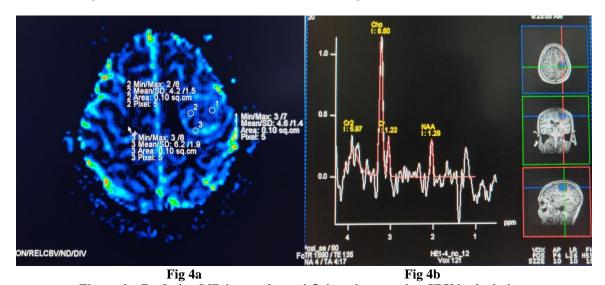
Perfusion MR image shows 4-5 times increase in rCBV in the lesion. Figure 4b: MRS(TE135) shows increase in choline and lactate peak and decrease in NAA peak in the lesion.
